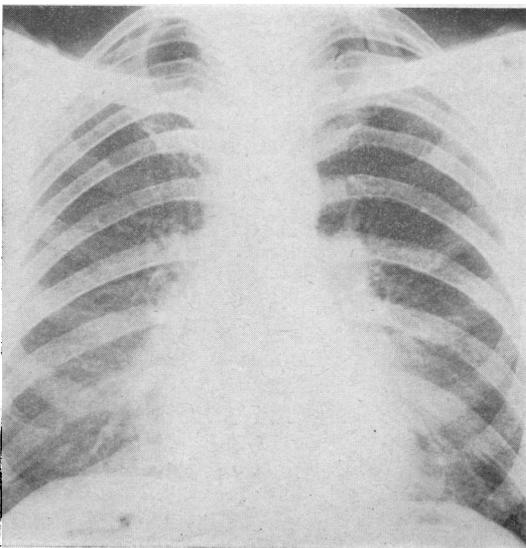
Case 3. Chest radiograph showing prominent hila and confluent mottling in both lungs, chiefly in lower zones.
